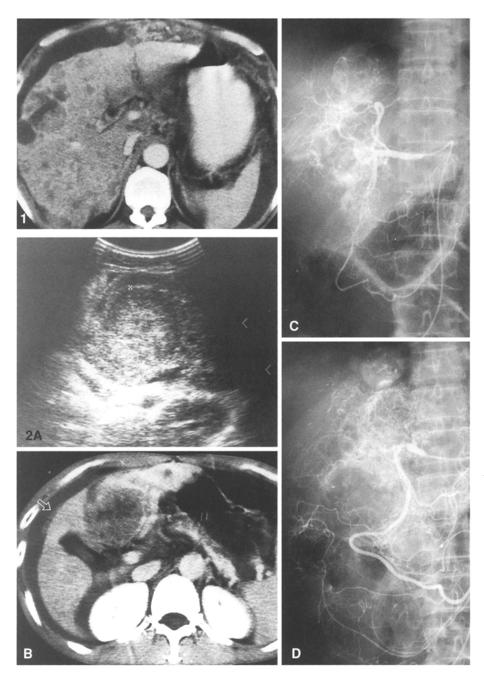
Case 1. CT demonstrates hepatic nodules, low attenuation in the portal vein suggesting thrombosis, peritoneal thickening, infiltrated omentum, and ascites.
